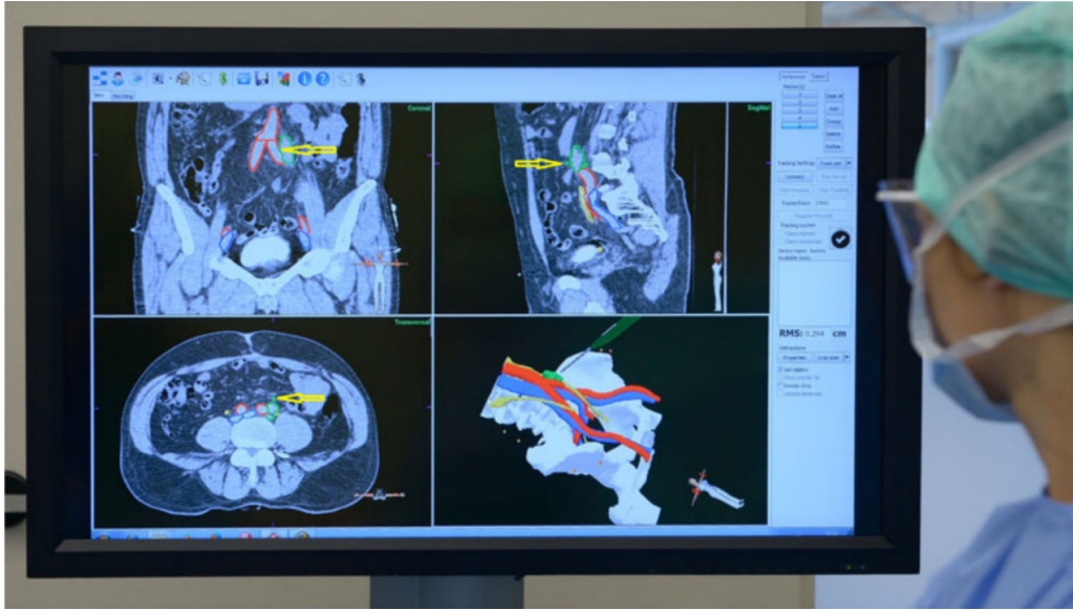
Intra-operative navigation user interface at the NKI-AvL. Three orthogonal views of a pre-operative CT-scan and a 3D model of five segmented structures are shown, namely bone (white), arteries (red), veins (blue), ureters (yellow) and a malignant lymph node (green). The surgical pointer is highlighted with yellow arrows in the CT-scan slices [17].
